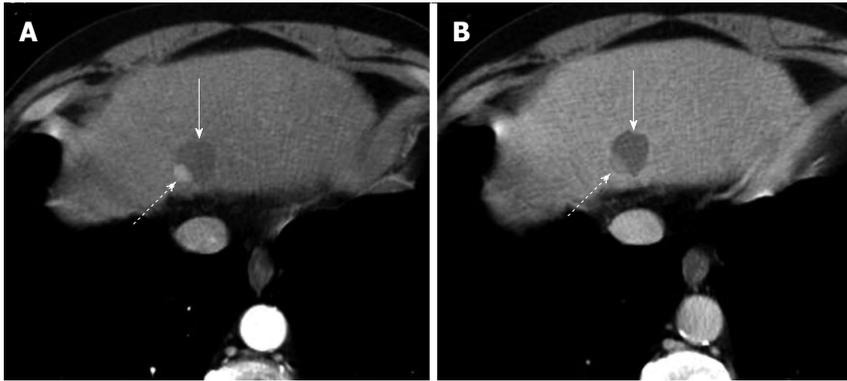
Incomplete hepatocellular carcinoma necrosis after percutaneous ethanol injection. Arterial (A) and portal venous (B) computed tomography obtained 1 mo after treatment shows that approximately 10%-20% of the tumor, located in the dorsal and lateral portion of the treated, hypoattenuating area, is still viable as demonstrated by the presence of enhancement in arterial phase and hypoattenuation ("washout") on portal venous phase (dotted arrow on A and B). The majority of tumor (solid arrow) does not show enhancement as a result of the treatment.
